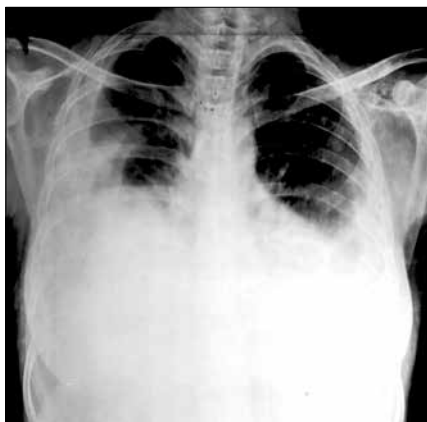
Chest X-ray showing bilateral pleural effusion (Right side more than left side)
